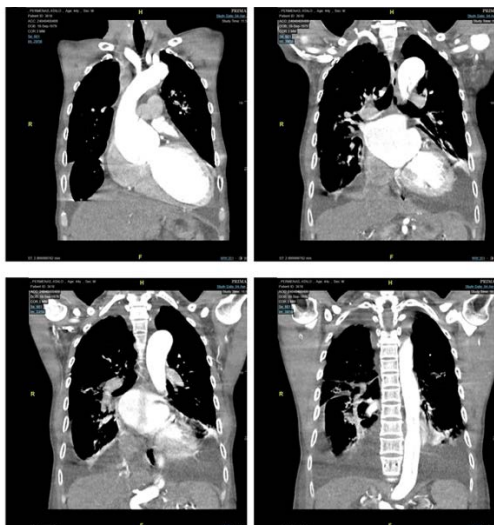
Contrast-enhanced thoracic CT scan
